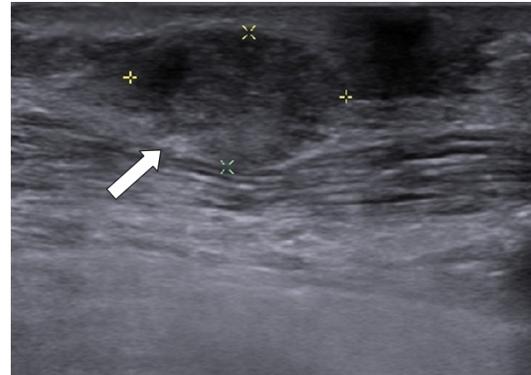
An ultrasonogram showing a well boundary inhomogeneous hypoechoic mass located in upper outer quadrant of the right breast.
